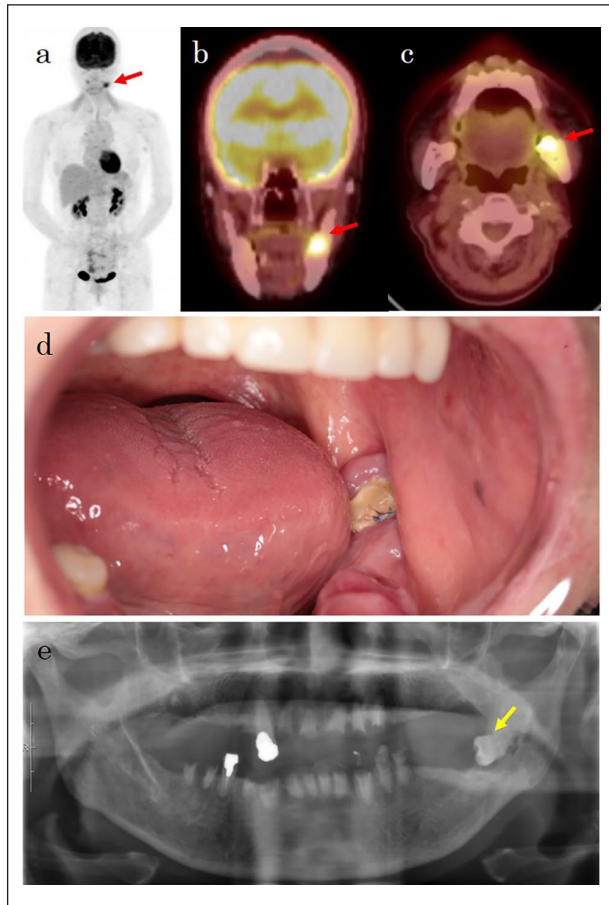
Diagnostic images and intraoral photographs: (a) Maximum intensity projection image obtained with F-18 fluorodeoxyglucose positron emission tomography showing intense uptake in the oral area (SUVmax 6.0, red arrow). (b) Coronal image obtained with F-18 fluorodeoxyglucose positron emission tomography/computed tomography showing intense uptake in the left mandibular area (red arrow). (c) Transverse image obtained with F-18 fluorodeoxyglucose positron emission tomography/computed tomography showing intense uptake in the left mandibular area (red arrow). (d) Intraoral photograph showing a bone-like tissue and swelling in the left mandibular gingiva. (e) Panoramic radiograph taken during long-term follow-up. The yellow arrow indicates the wisdom tooth in the left mandible.
